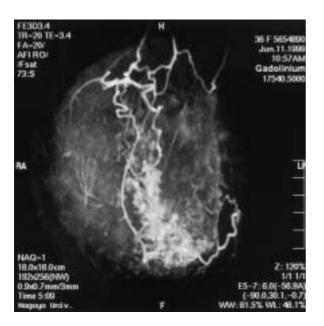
Diagnostic imaging of the spread of breast cancer by MRI
